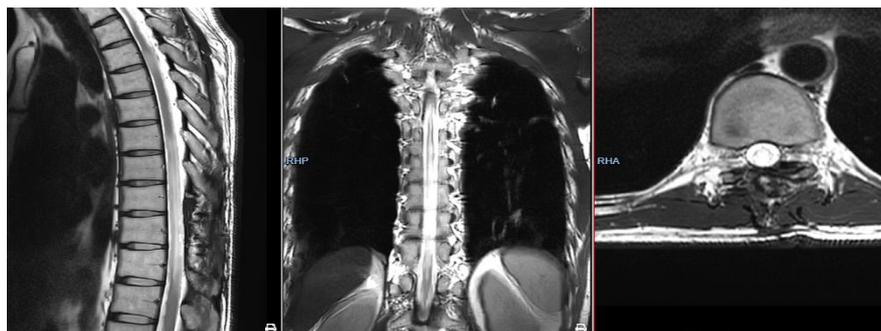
MRI control 2 years after surgery
